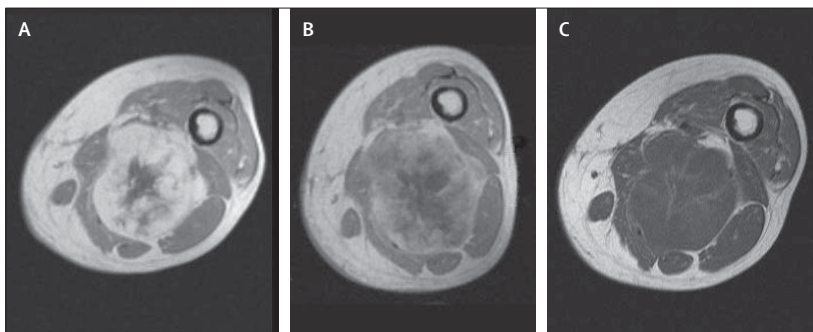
MRI of left thigh showing progressive decrease of contrast enhancement without tumour shrinkage in patient 26
